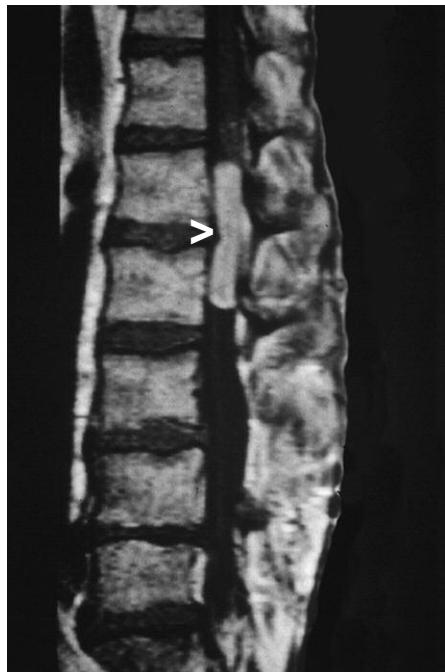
MRI of a myxopapillary ependymoma of the filum terminale (arrow) presenting as a hyperintense spinal mass.
